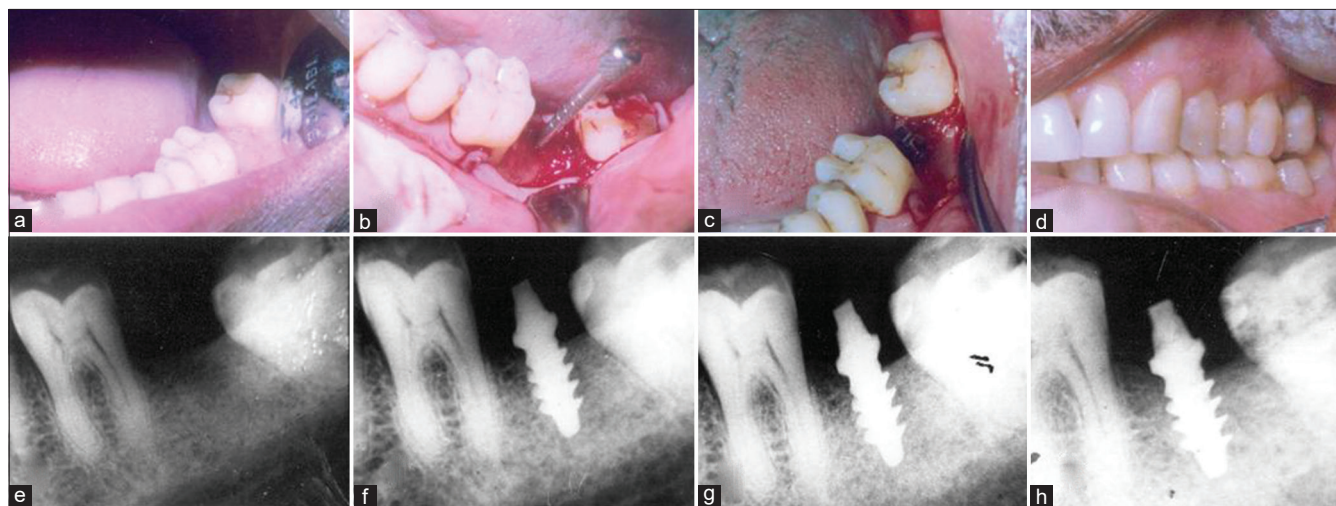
Edentulous site of left second molar implanted with 4.5 width threaded screw implant and restored (a) Preoperative view (b) depth gauge placed in the osteotomy (c) Implantation into osteotomy (d) Temporization with acrylic crown in infra-occlusion. Follow up radiographs (e) Preoperative (f) 1 month postoperative (g) 6 months postoperative (h) 1 year postoperative
